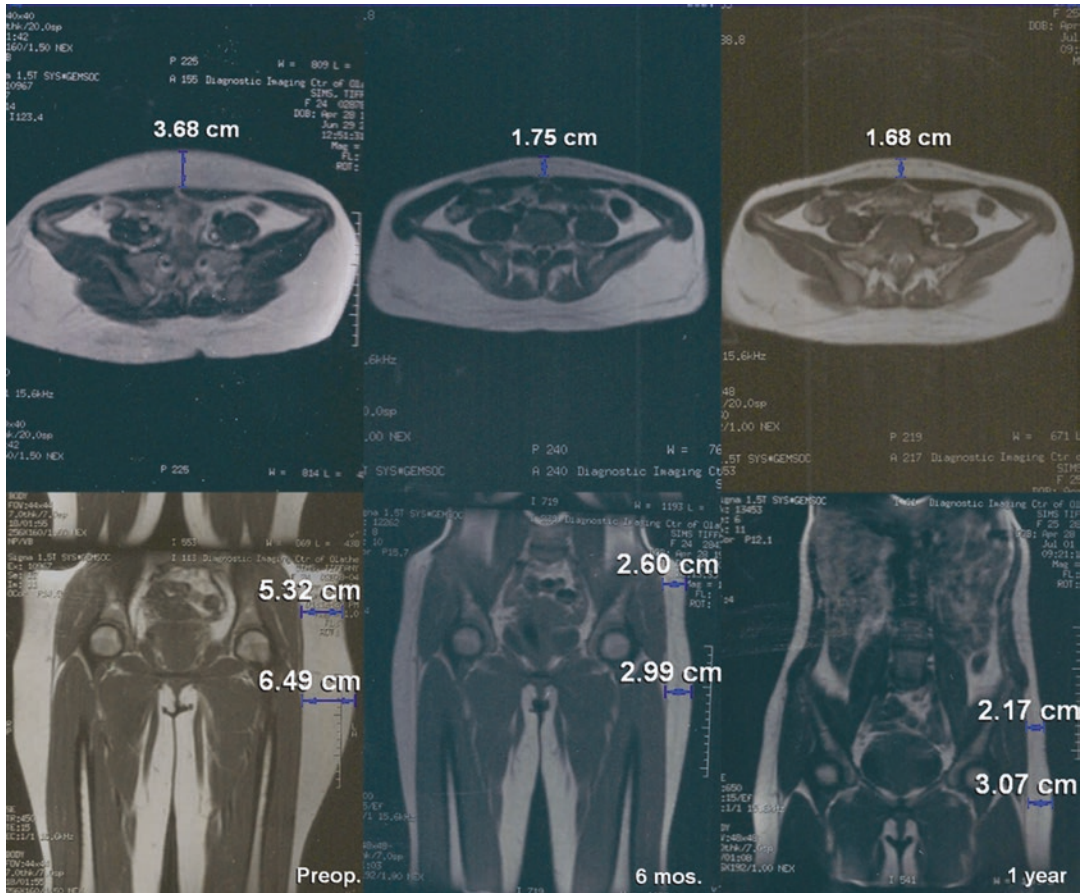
This 24-year-old woman’s clinical photographs are shown in Figs. 2.2, 2.5, and 2.6. Axial abdominal (above) and coronal lower body (below) magnetic resonance imaging scans were taken before (left), 6 months after (center), and 1 year after (right) liposuction of her lower body, arms, and axillae and a breast augmentation. The subcutaneous fat appears white in these T1-weighted images. Measurements are indicated at the level of the abdomen, left flank, and thigh. One year after surgery
